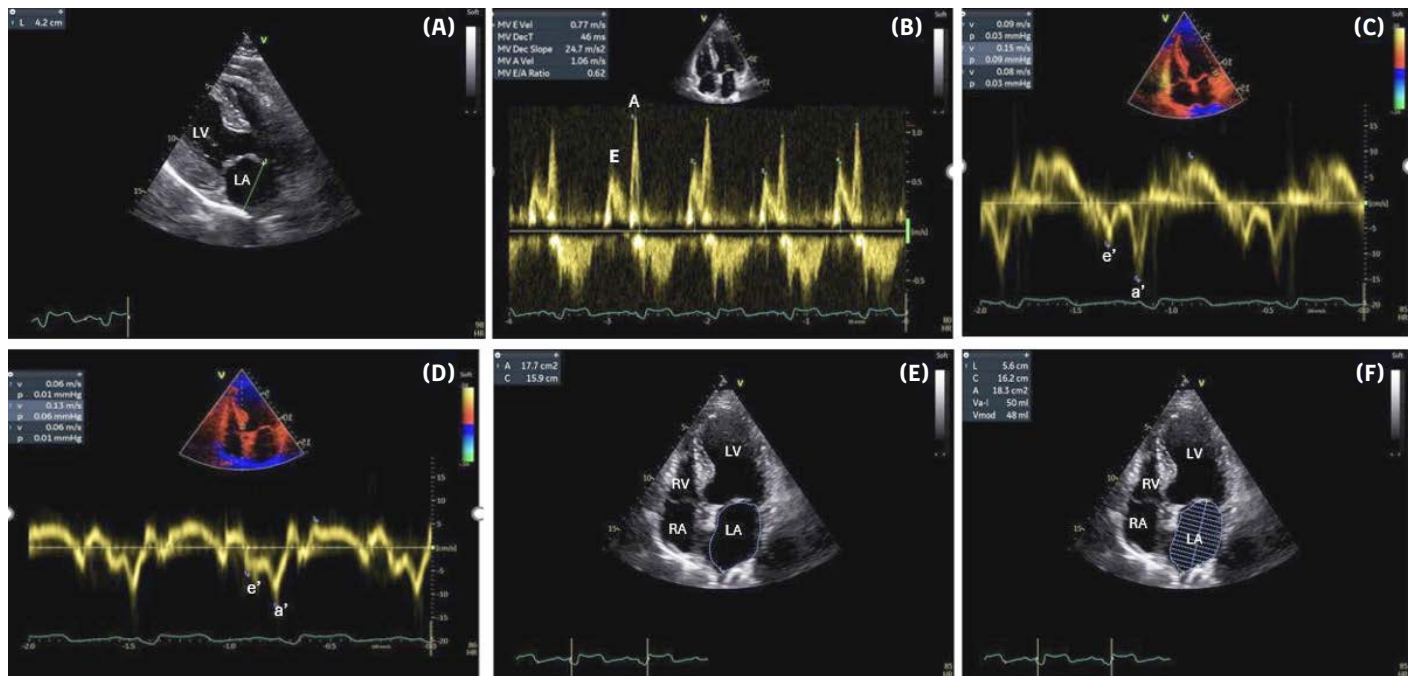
Echocardiographic assessment of left atrial size and left ventricular diastolic function in a patient with erectile dysfunction. * (A) Parasternal long-axis view showing marked left atrial (LA) enlargement posterior to the left ventricle (LV). (B) Pulsed-wave Doppler recording of mitral inflow velocities demonstrating reduced early (E) to late (A) diastolic filling ratio ($E/A = 0.62$), indicating impaired diastolic relaxation. (C) Tissue Doppler imaging (TDI) from the lateral mitral annulus showing reduced early diastolic annular velocity (e') and relatively preserved late diastolic velocity (a'), consistent with abnormal LV relaxation. (D) TDI from the septal mitral annulus showing similarly decreased e' and elevated a' , reinforcing evidence of diastolic dysfunction. (E) Apical four-chamber view with manual planimetry outlining left atrial area (LA), alongside right atrium (RA), right ventricle (RV), and left ventricle (LV). (F) Biplane method of disks for left atrial volume quantification, highlighting enlarged LA dimensions.
